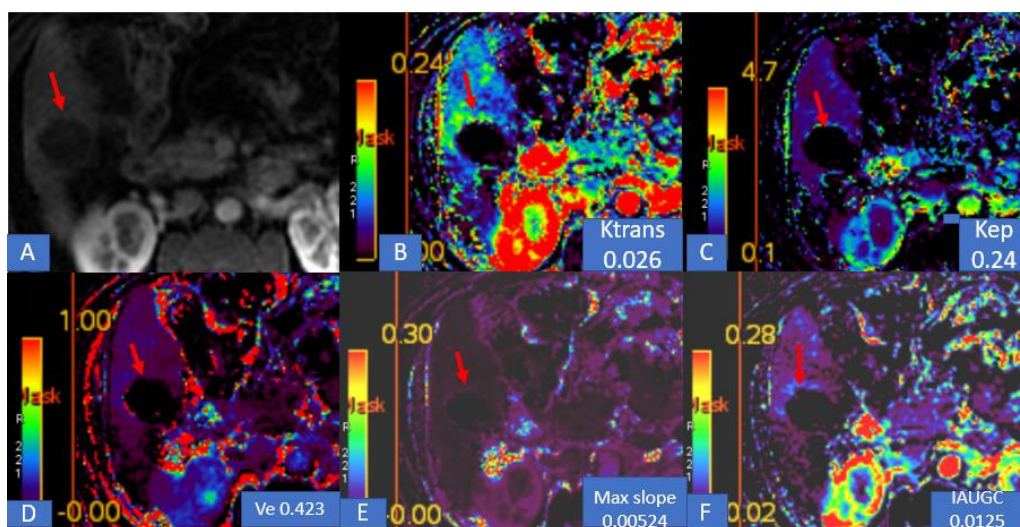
MR perfusion images in same patient with complete response. A- MR perfusion Contrast-enhanced image showing complete response with no enhancement in the lesion(arrow); B-F colour-coded maps of Ktrans(B), Kep(C), Ve(D), Max slope(E), IAUGC(F) (arrows) . Decreased Ktrans, Kep, max slope, IAUGC, and Ve noted in postTACE MRI indicating response.
